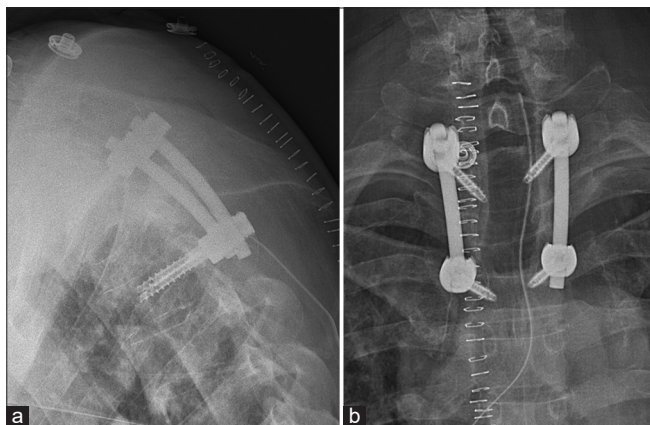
Postoperative plain radiograph imaging in the (a) sagittal and (b) coronal plane.
